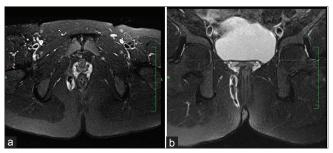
T2-weighted fat suppression axial and coronal: Suprasphinteric fistula in right buttock with external opening at 7 o' clock position and internal opening at 6 o' clock position
